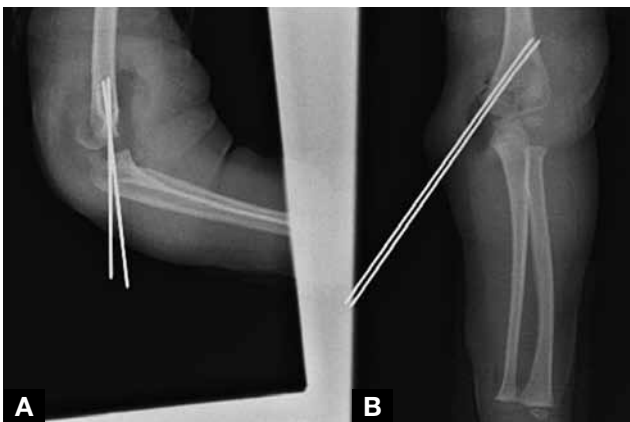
Initial intraoperative (A) lateral and (B) anteroposterior (AP) radiographs. These radiographs were taken after open reduction and internal fixation of the medial condyle fracture. The lateral view clearly shows the posteriorly displaced lateral condyle fracture that remains displaced. The AP view shows the fracture but underestimates the displacement.
